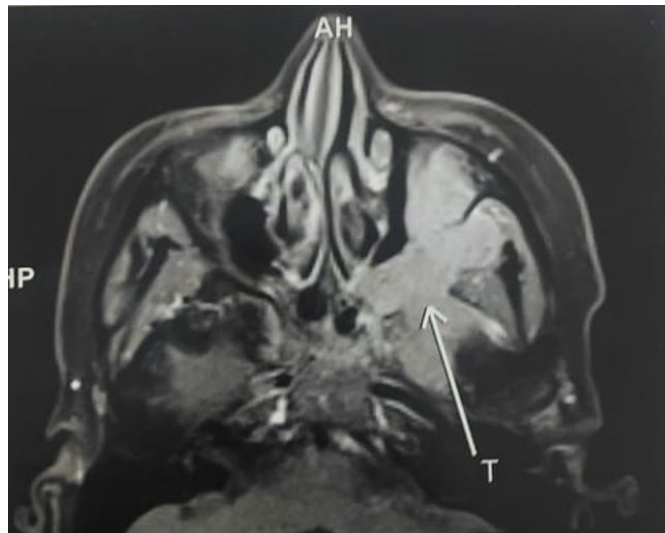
MRI axial sections showing a hypo-isointense mass in the left infratemporal fossa on T1 and T2 weighted images, extending to the maxillary sinus and the lateral and inferior walls of the left orbit.
